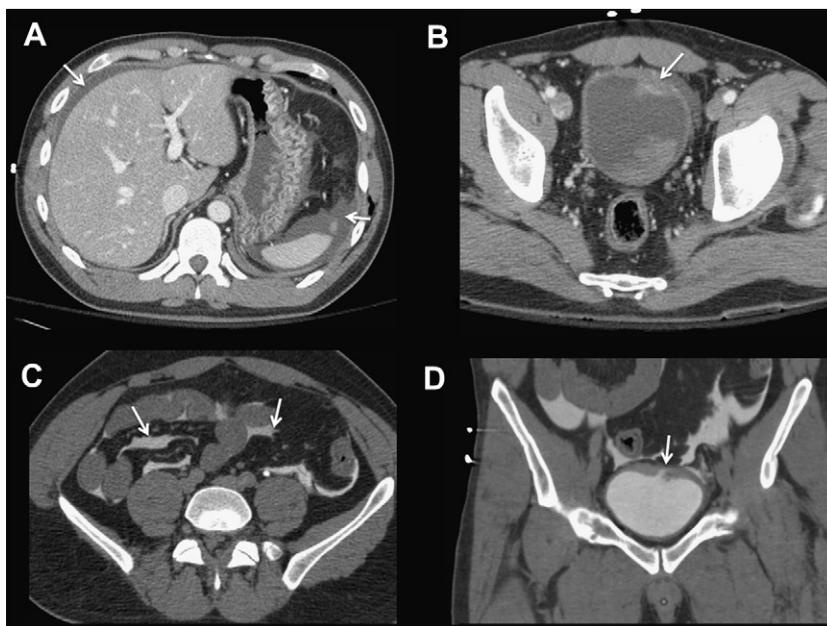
Intraperitoneal bladder rupture. (A) Axial intravenous contrast-enhanced portal venous phase CT scan demonstrates low- to mixed-density fluid around the liver and spleen (*white arrows*). (B) Axial intravenous contrast-enhanced portal venous phase CT scan through the bladder demonstrates high-attenuation clot layering dependently in the bladder with thickening along the left anterolateral bladder wall (*white arrow*). (C) CT cystogram image demonstrates free contrast in the peritoneal cavity interdigitated among bowel loops and leaves of mesentery (*arrows*). (D) Coronal image demonstrates focal interruption of the dome of the bladder with extravasation of contrast into the peritoneal cavity (*arrow*).
